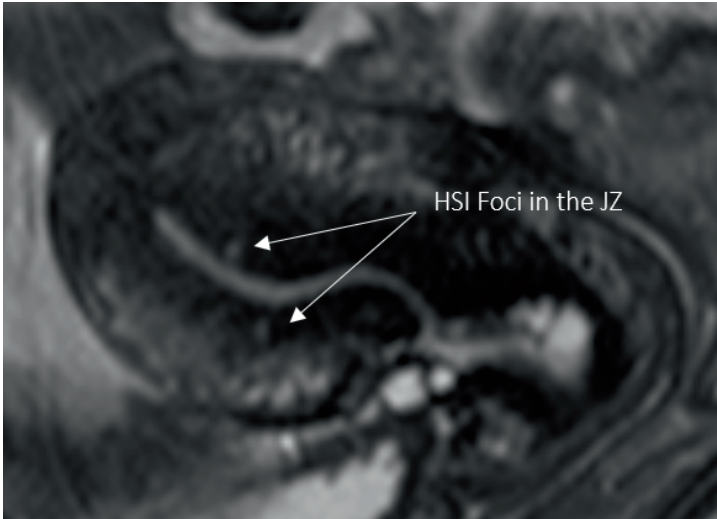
Sagittal T2W MRI showing subtle high signal intensity (HSI) foci in the junctional zone (JZ)
